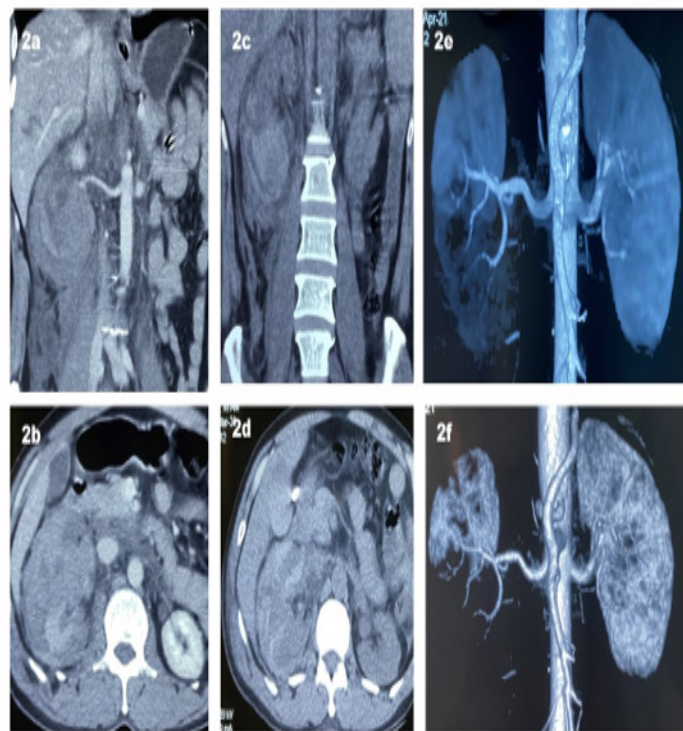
CT scan done in a Pt. (33-year-old) with Grade IV injury, on admission.
